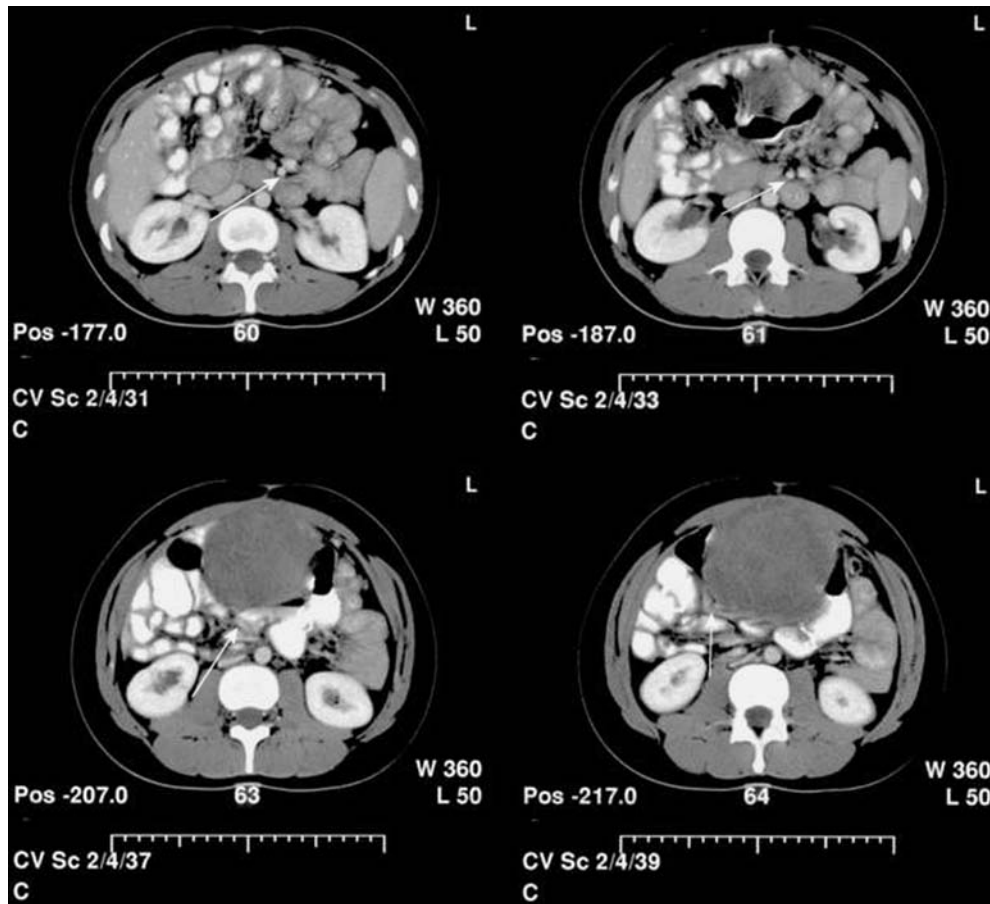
CT scan of intra-abdominal tumour showing relationship with superior mesenteric artery (highlighted with arrows). In this case the proximal SMA is free from tumour, making the lesion potentially resectable.
